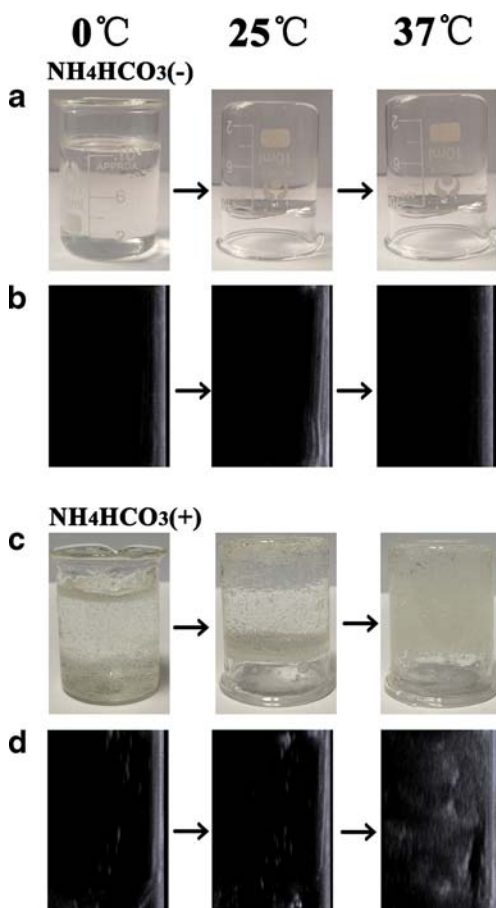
Gelation and bubbles of non-floating and floating hydrogel. (a) Gelation of non-floating hydrogel, (b) bubbles produced by non-floating hydrogel recorded by B ultrasound, (c) gelation of floating hydrogel, (d) Bubbles produced by floating hydrogel recorded by B ultrasound.
